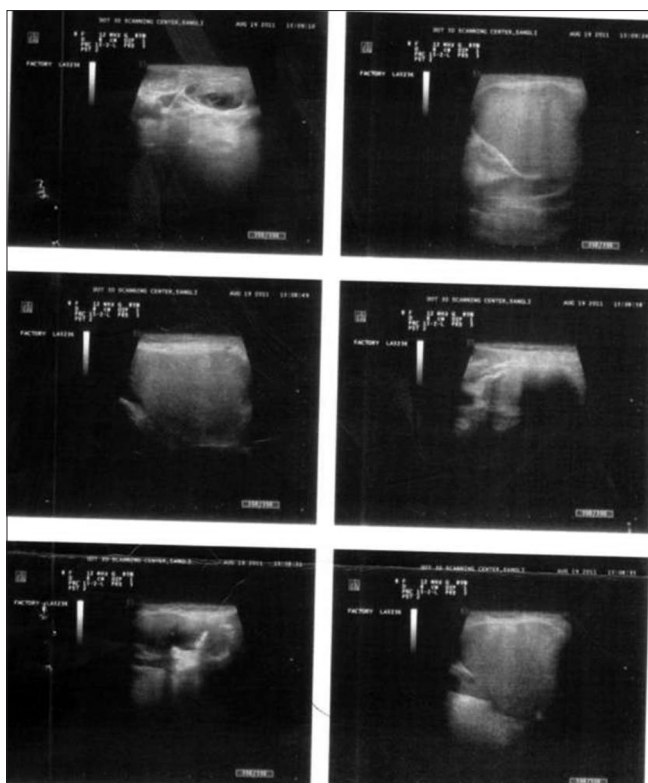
Ultrasound scan showed an evidence of large lobulated cystic mass noted in the left submandibular region. Fluid shows internal echoes and calcification within
